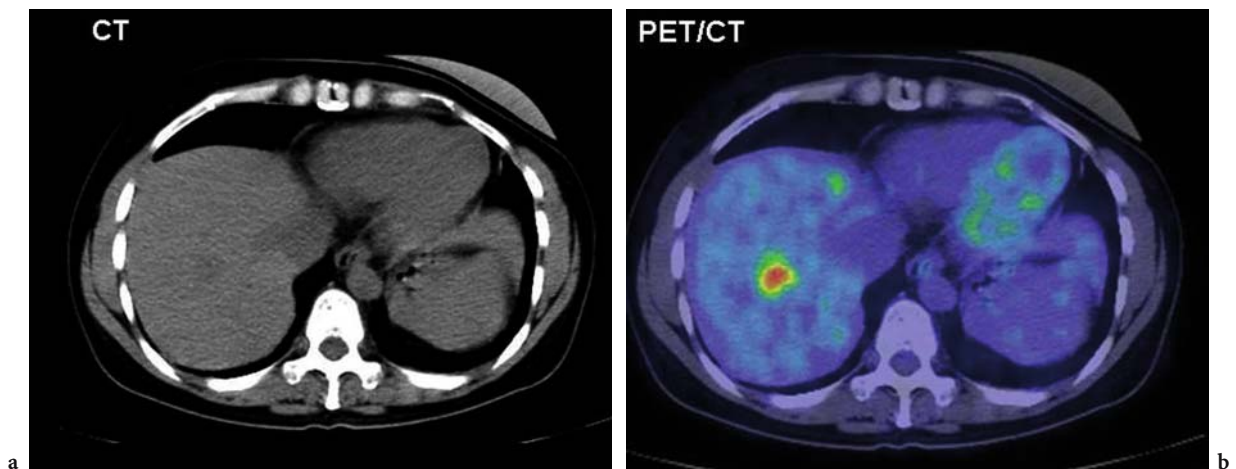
Patient surgically treated for breast cancer and presenting an increasing serum marker value: a single liver metastasis was detected by PET/CT
